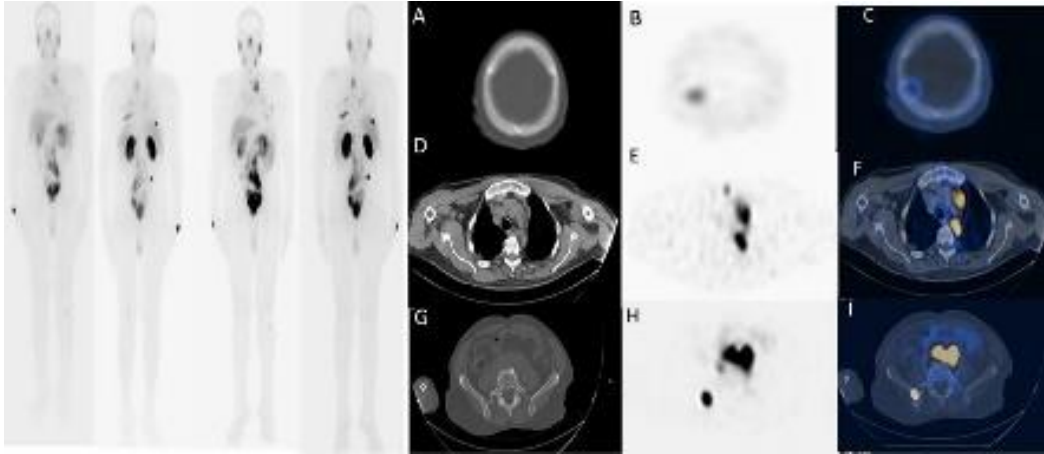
Whole body PSMA planar imaging showing physiologic PSMA uptake along with abnormal foci of tracer uptake in the skull, upper chest, left 8th rib posteriorly, abdomen and pelvis. A, B and C are SPECT/CT images of radiotracer uptake in right parietal bone. D, E and F are SPET/CT images of radiotracer uptake in left mediastinal lymph node. G, H and I are SPET/CT images of radiotracer uptake in right ilium near right sacro-iliac joint, respectively
